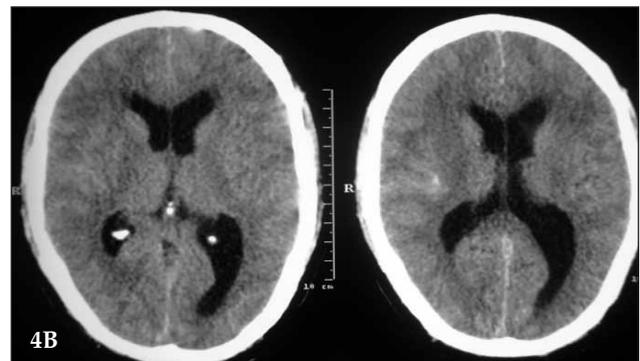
Presence of extensive areas of restricted diffusion in preoperative DWI image (A) and absence of infarct in postoperative CT scan (B).
